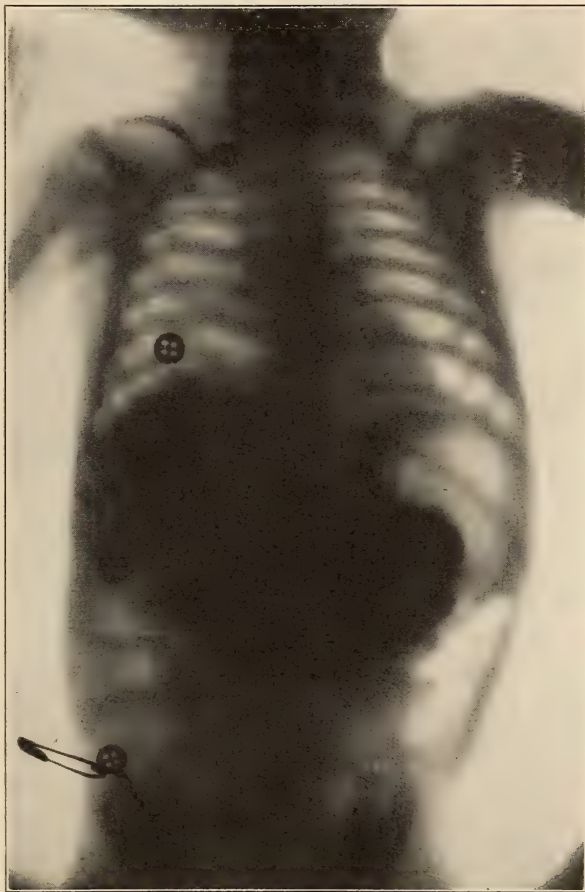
PYLORIC STENOSIS. (Radiograph.)
